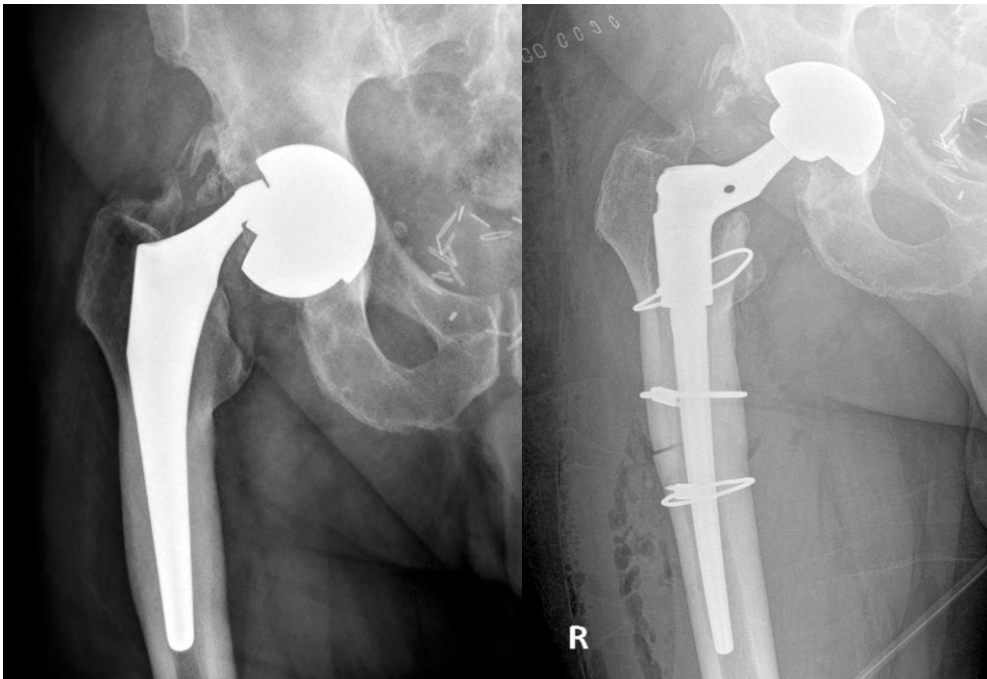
24a (left) Anteroposterior radiograph showing the femoral head dissociated from the trunnion after THA. 24b (right): Anteroposterior radiograph showing the outcome after revision surgery with an Arcos 12x150mm STS distal bearing stem and a cone B 60 High-Offset proximal body.
